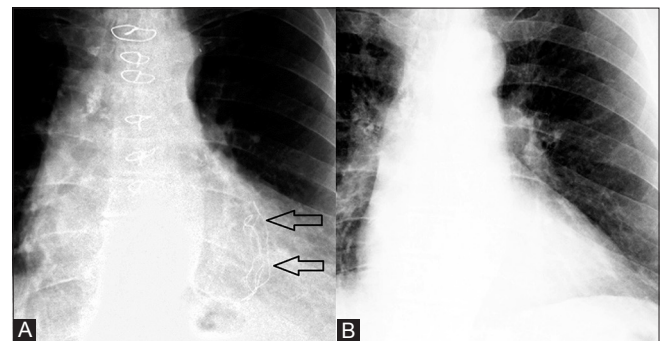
(A, B): Radiopaque sponge markers in a 68-year-old male patient who had undergone coronary artery bypass graft surgery 1 month earlier. Posteroanterior chest radiograph taken after cardiovascular surgery (A) shows folded linear radiopaque sponge markers (arrows) superposed on the left side of the heart that was not there on the preoperative chest radiograph (B)
